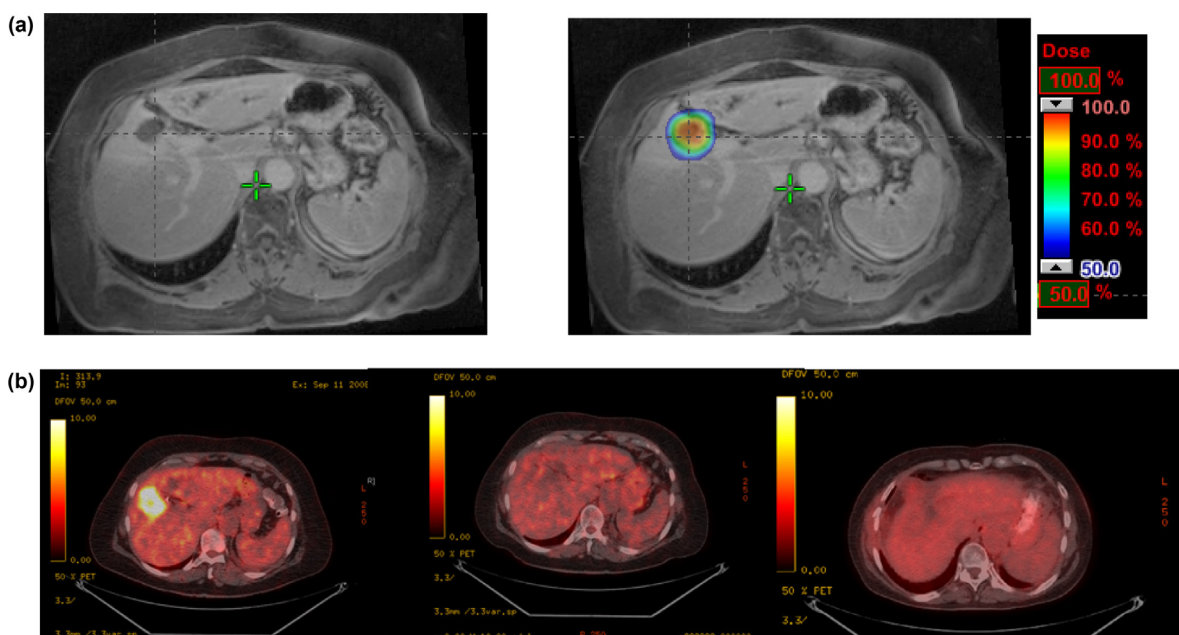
72-Year old female with liver metastases from NSCLC. (a) Diagnostic abdomen MRI and dose in color wash in planning treatment using MRI fusion. Dose: integrated boost (12 Gy in the periphery and 15 Gy in the center of the lesion) \times 3 fractions. (b) PEC CT at diagnosis and consequently follow-up at 3 months, 5 years and 11 months after SBRT completion, respectively, showing complete response.
